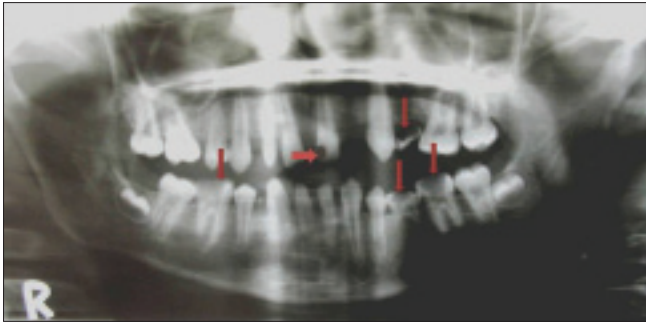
Orthopantomogram depicting congenitally missing lateral incisors and second premolars and multiple carious teeth
